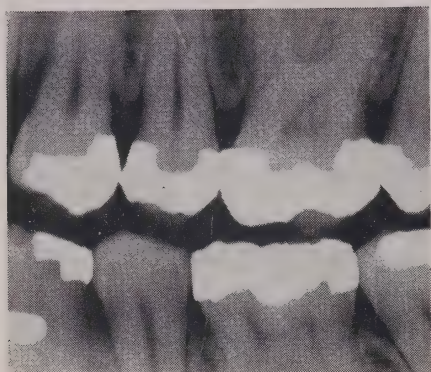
X-ray of distoclusal amalgam restoration of upper first bicuspid after separation and polishing.
